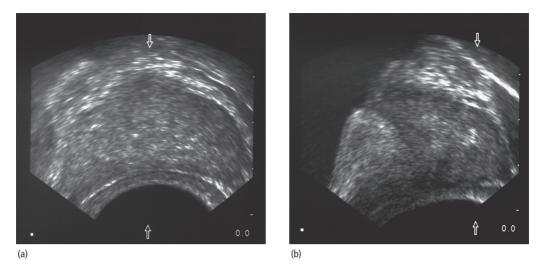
Transrectal ultrasound (TRUS) examination of the prostate: (a) transverse and (b) longitudinal.
